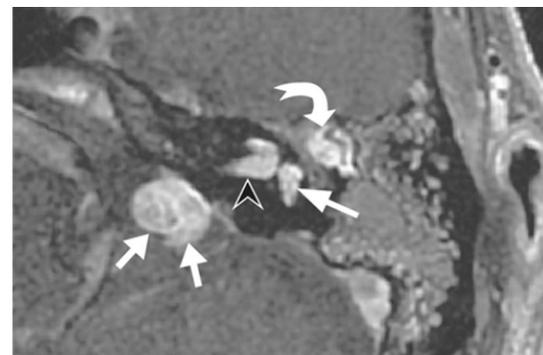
Case 3, vestibular schwannoma extending towards the middle ear through the inner ear in a patient with type 2 neurofibromatosis. Contrast-enhanced axial T1-weighted sequence showing a vestibular schwannoma in the internal auditory canal (arrow head) and the cerebellopontine angle (double white arrows) extending towards the inner ear, completely filling the cochlea and the vestibule (arrow) and developing in the middle ear (curved arrow), where it surrounds the ossicles
